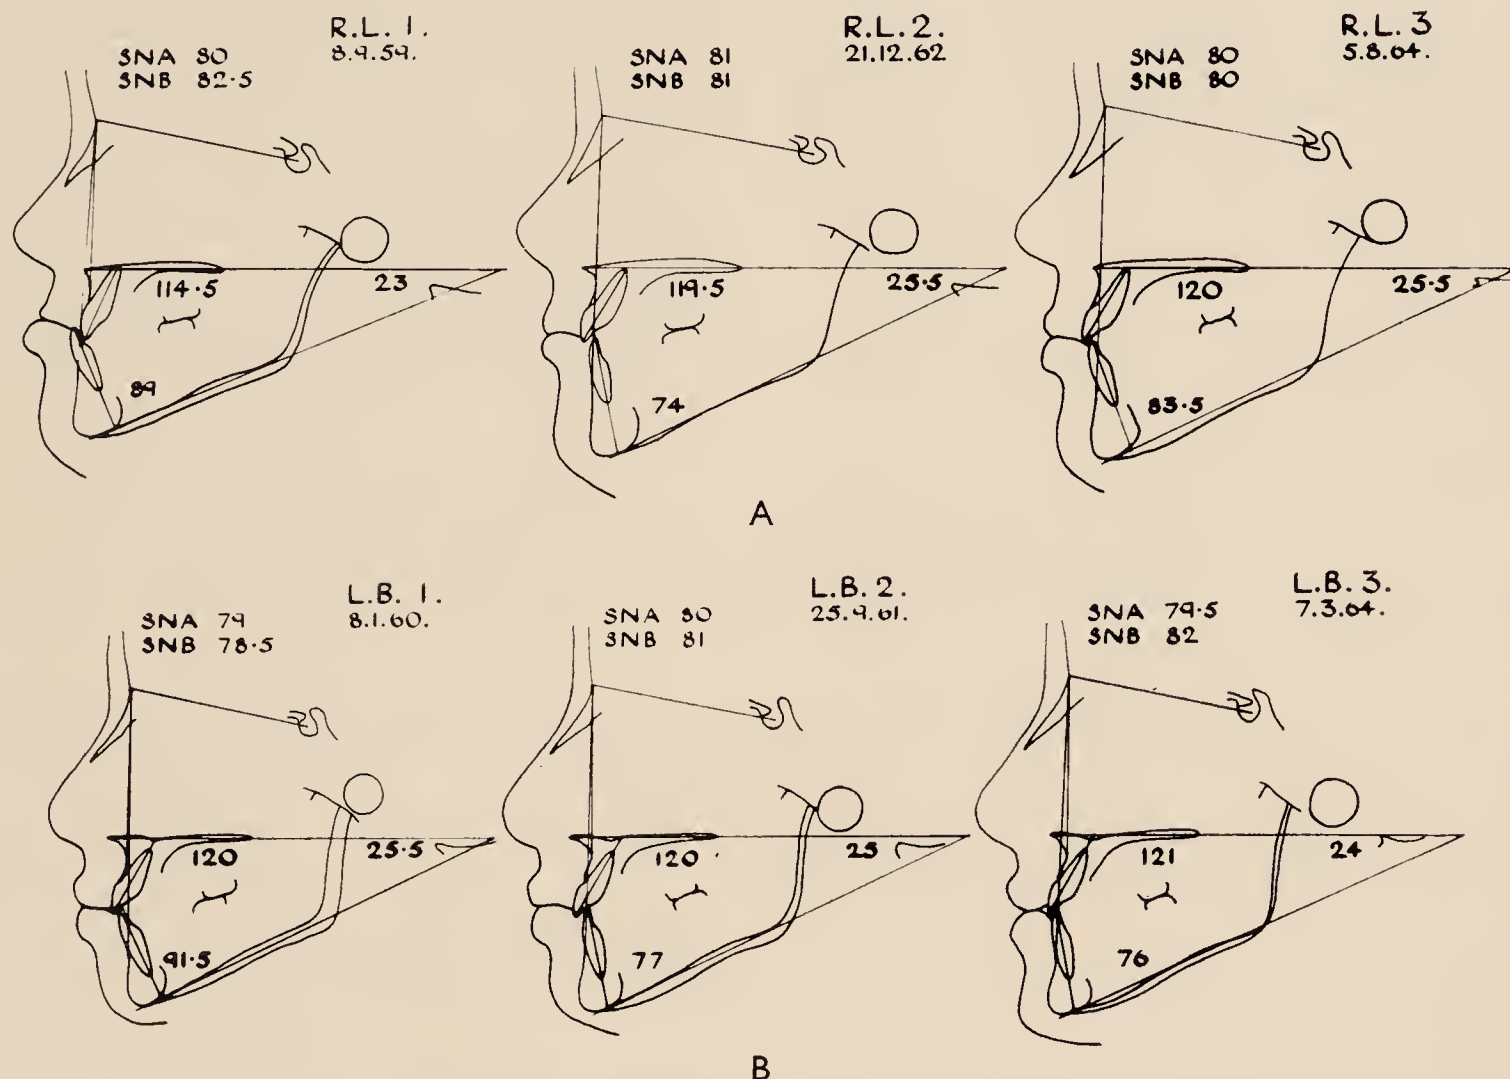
Tracings of lateral skull radiographs. A, Case R.L. B, Case L.B.
